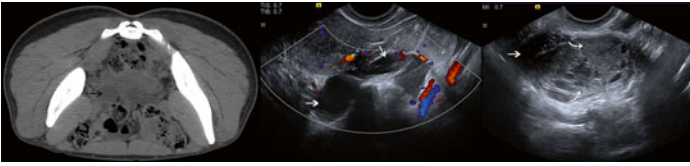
Axial CT of the pelvis with corresponding sagittal Doppler and coronal US images of the left adnexa. While CT is able to show a multiloculated low-density fluid collection (*black arrows*) within the pelvis, further characterization is difficult. Follow-up US images demonstrate that the fluid is contained within tubular structures (*white arrows*) in continuity with a dilated, heterogeneous appearing ovary (*curved white arrows*), allowing for diagnosis of tubo-ovarian abscess.
